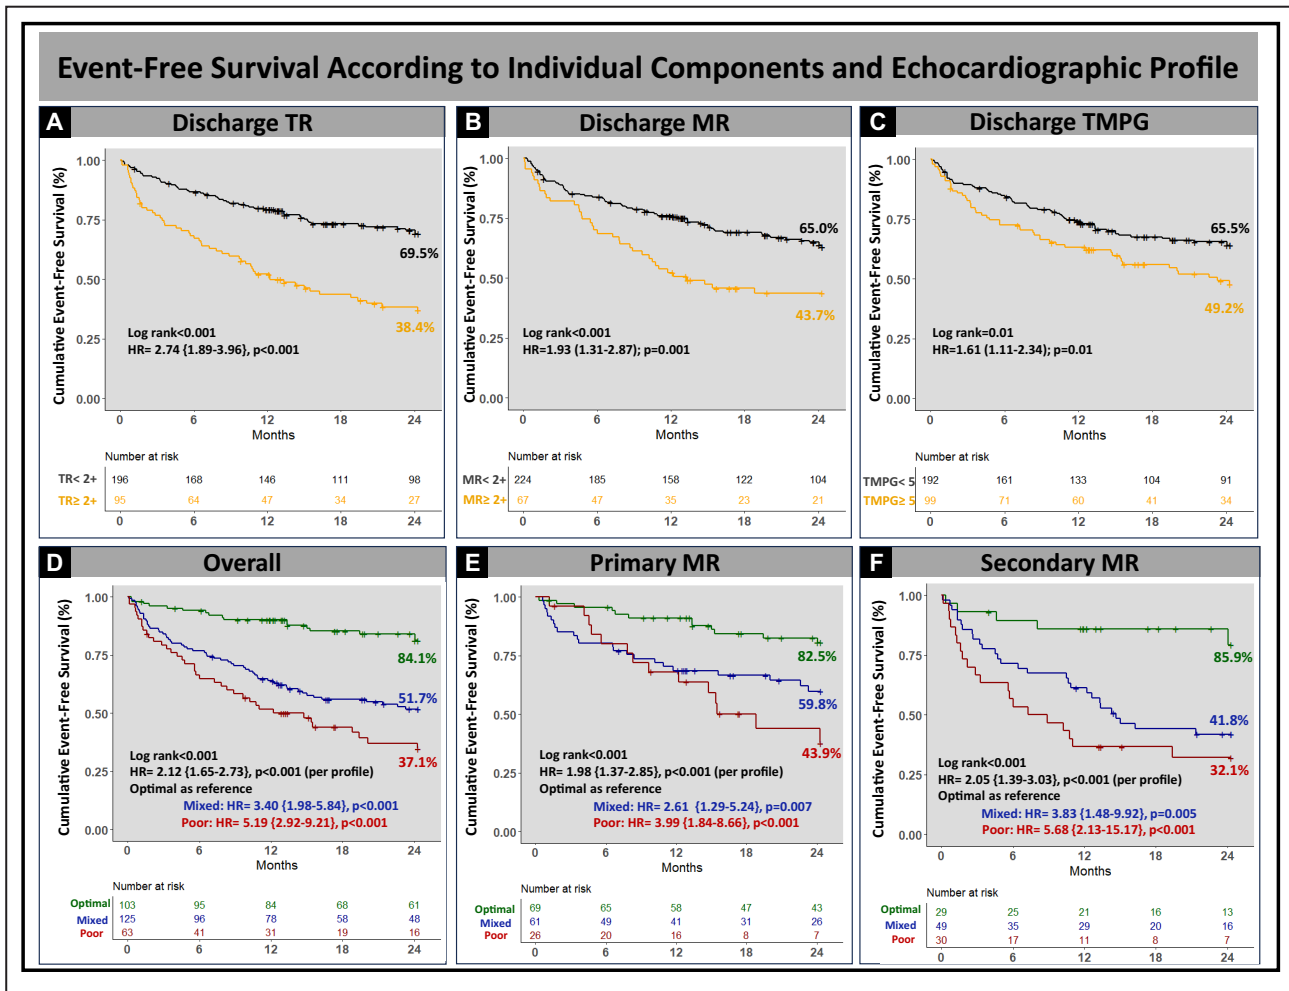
Event-free survival based on individual components and echocardiographic profile. Cumulative event-free survival was associated with each component of the hemodynamic profile, with lower 2-year cumulative event-free survival in patients with pre-discharge TR \geq moderate (A), MR \geq moderate (B), and pre-discharge TMPG \geq 5 mmHg (C); and the intraprocedural hemodynamic profile with lower 2-year cumulative event-free survival overall. Compared with patients with poor profile, optimal profile had superior event survival overall (D) and in patients with primary (E) and secondary (F) MR. HR indicates hazard ratio; MR, mitral regurgitation; TMPG, transmitral mean pressure gradient; and TR, tricuspid regurgitation.
